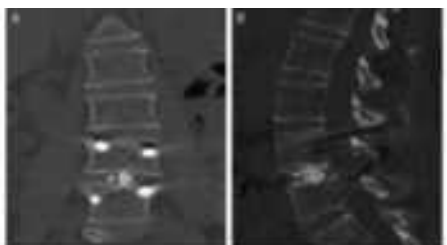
Example of transforaminal lumbar interbody fusion. A and B, Coronal and sagittal computed tomographic scans of a 49-year-old woman, 7 years after surgery.
